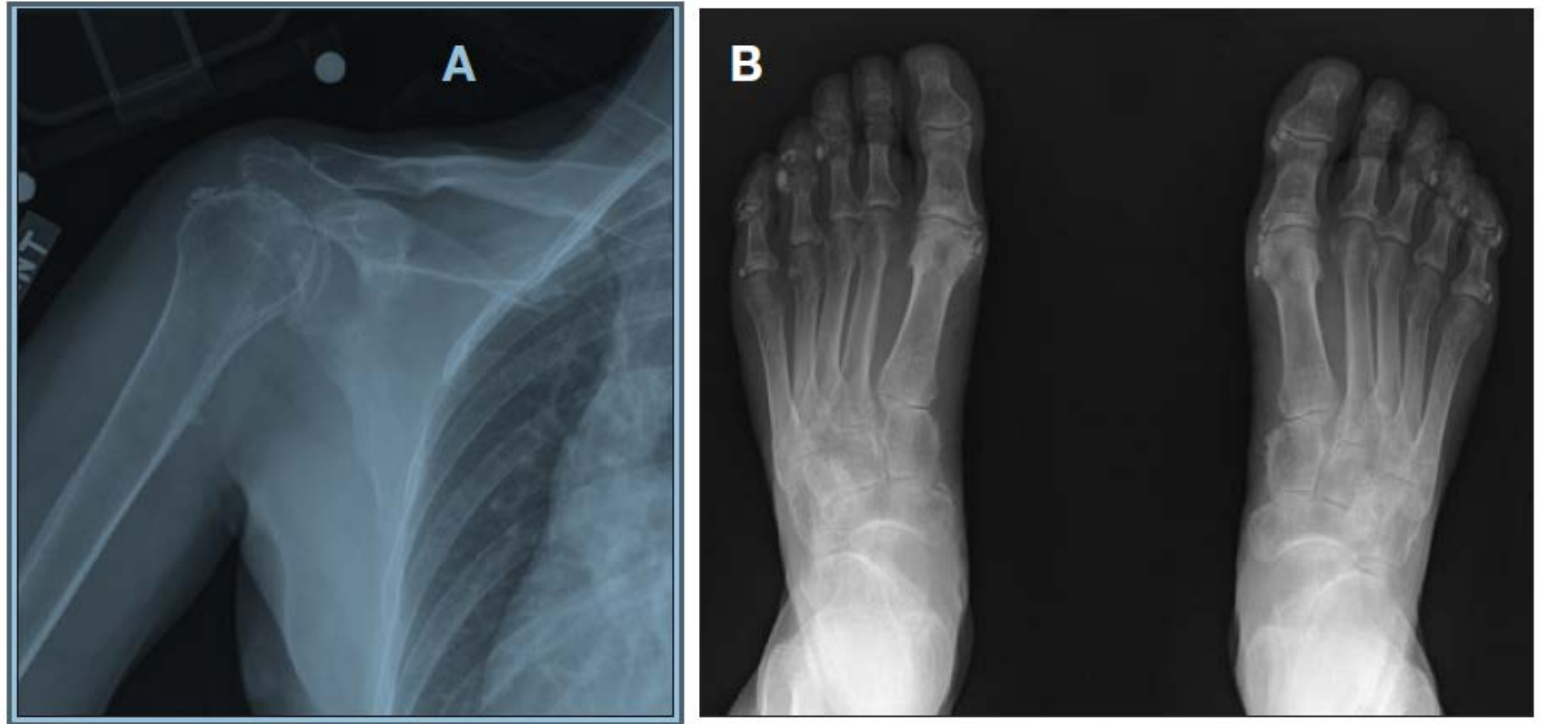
Plain radiograph demonstrating periarticular calcifications in the right shoulder (A) and both feet (B).
